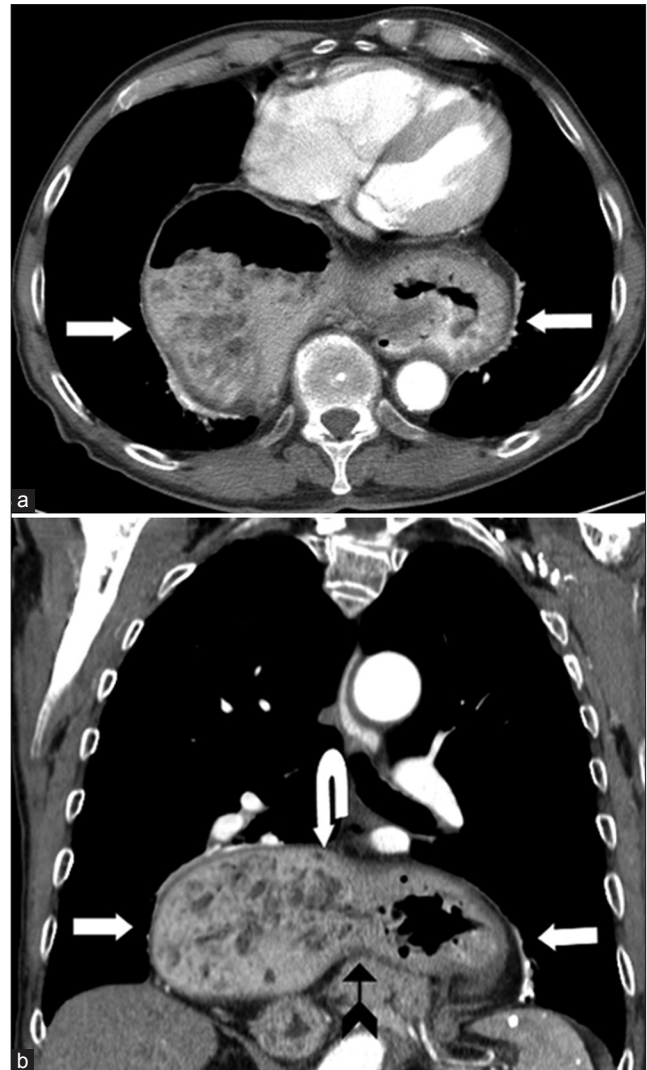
Axial and coronal chest CT. (a) Axial CT image shows the stomach (straight white arrows) within the thorax, posterior to the heart, consistent with a large gastric hernia. (b) Coronal CT image shows the stomach (straight white arrows) above the diaphragm, within the chest, compatible with a large gastric hernia. Additionally, the greater curvature (curved white arrow) of the stomach is positioned superior to the lesser curvature (straight black arrow) indicative of an organoaxial volvulus
